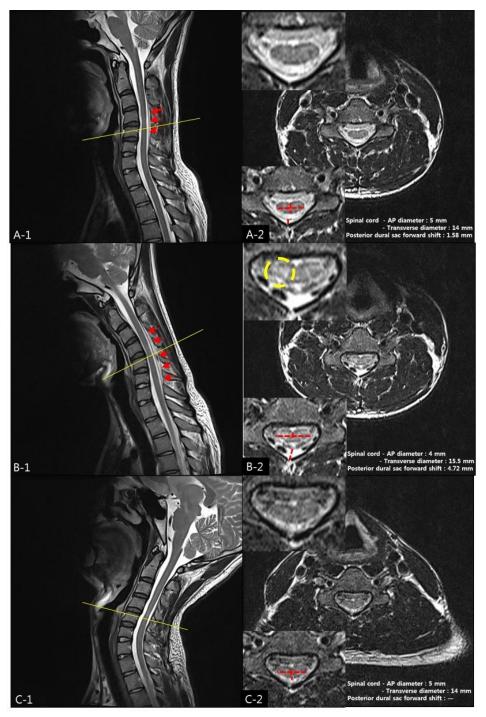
(A-1) Midline sagittal T2- weighted magnetic resonance imaging of the cervical spine in the neutral position reveals subtle anterior displacement of posterior epidural space (red arrows) between C2/3-C5/6 with reversed lordosis and (A-2) subtle spinal cord atrophic change, C4/5 level at axial view . (B-1) Anterior displacement and widening of posterior epidural space, with internal engorged venous structure at C3 to C7, most prominently at C4/5 level. (B-2, C) There is further compressing spinal cord at C4/5 level with segmental atrophic change and subtle myelopathy, which are reversible on extension
